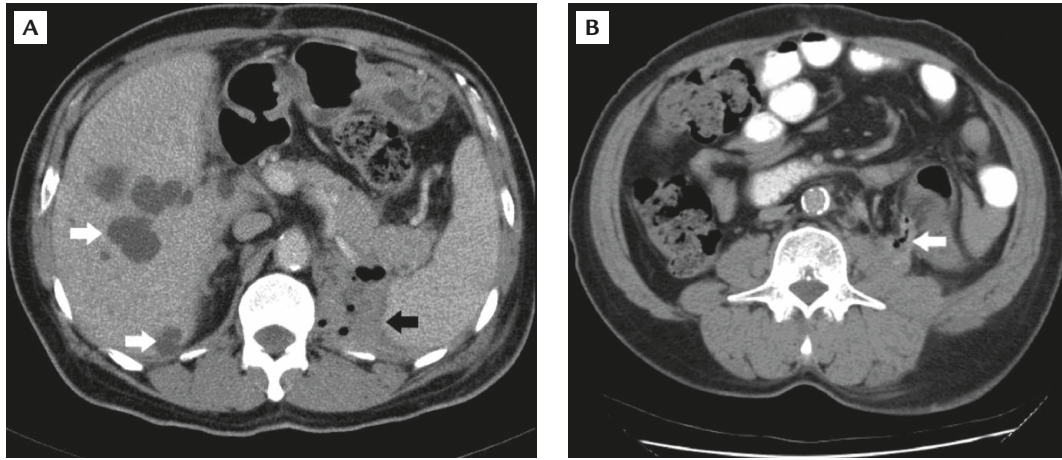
(A) Computed tomography shows a relatively well-demarcated heterogeneous, low-density lesion and gas bubbles in the left suprarenal region (black arrow). Several low-density hepatic cysts (white arrows) were observed in our patient, who had undergone bilateral nephrectomy. (B) A gas-containing track (arrow) communicating with the descending colon and retroperitoneum was observed, just anterior to the left psoas muscle.
